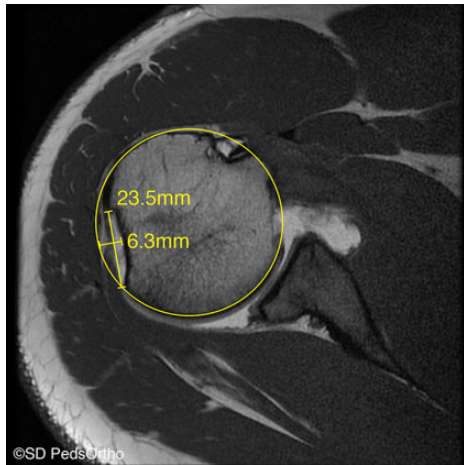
Axial T1-weighted magnetic resonance image of a large Hill-Sachs lesion with minimal glenoid loss that underwent a remplissage procedure. The width and depth of the Hill-Sachs lesions were measured on the axial slice, demonstrating the largest size of the lesion in the plane of the infraspinatus tendon insertion. Image courtesy of SD PedsOrtho.
